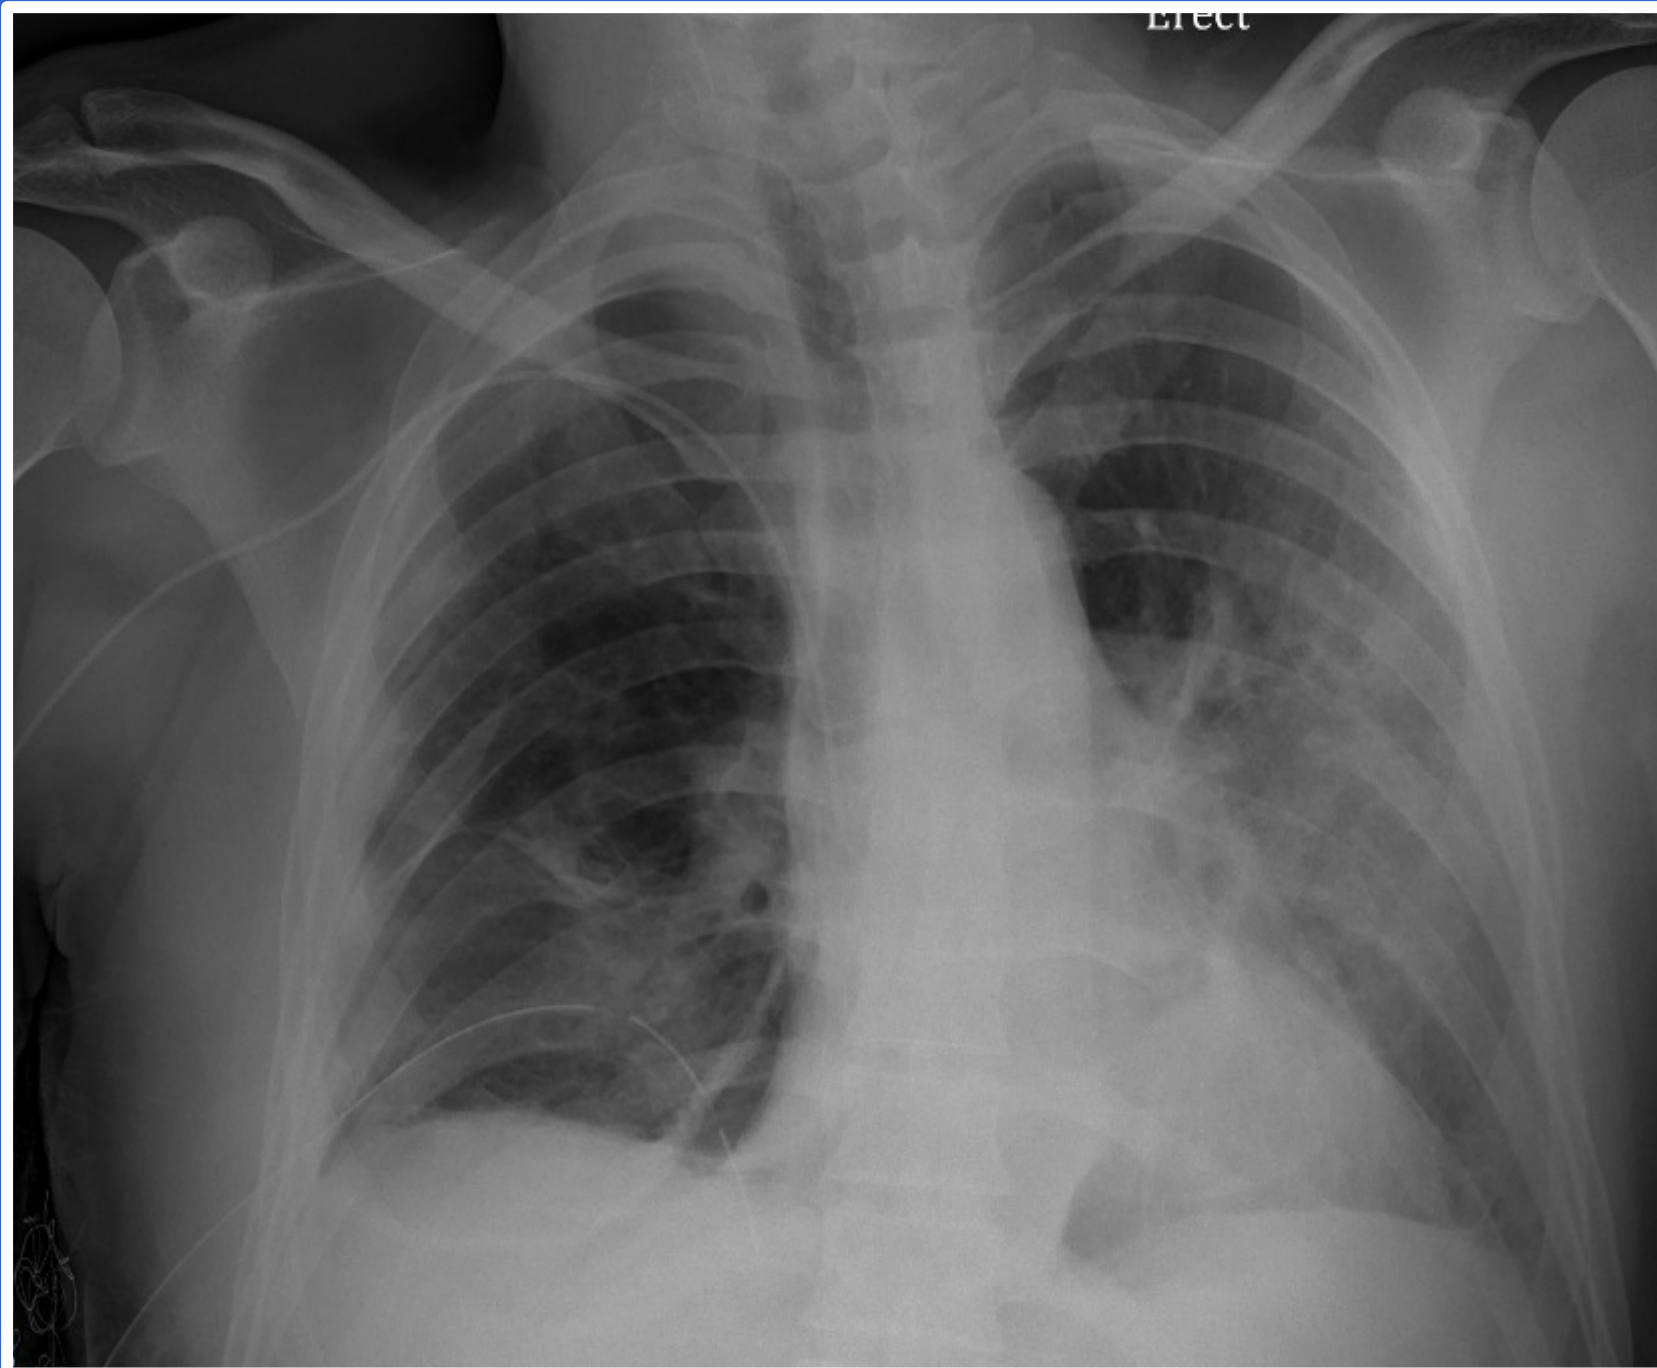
AP chest x-ray demonstrating upsizing to two 28F thoracostomy tubes in right hemithorax.
